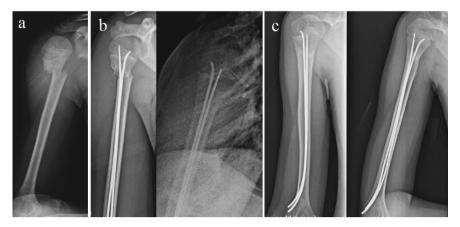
Metaphyseal fracture of the proximal humerus: (a) treated with elastic intramedullary nailing; X-ray before removal of the fixation devices (b), and after showing complete fracture healing (c)
